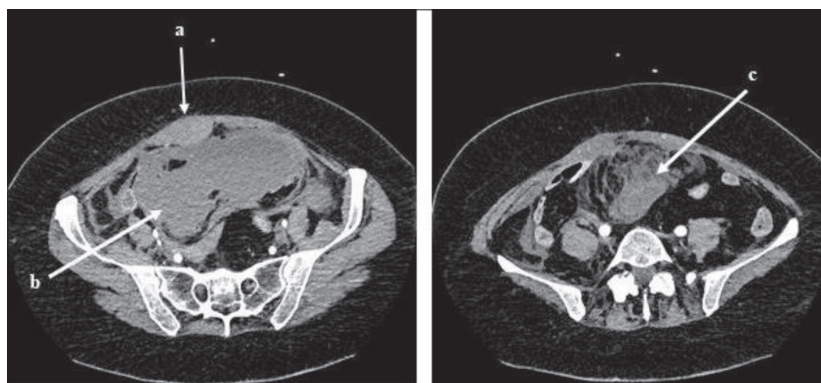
Case 1 – (a) axial computed tomography scans of the abdomen and pelvis show right rectus abdominis muscle hematoma (b) extending into the extraperitoneal pelvis; (c) hemorrhagic collection posterior to the anterior abdominal wall
